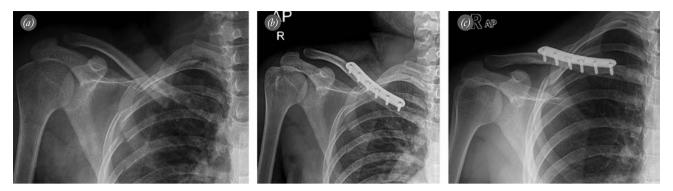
(a) Preoperative anteroposterior shoulder radiograph of a 25-year-old female patient showing right midshaft clavicle fracture with 2 cm shortening (b) Postoperative radiograph of the shoulder. (c) Control radiograph at 12 months.
